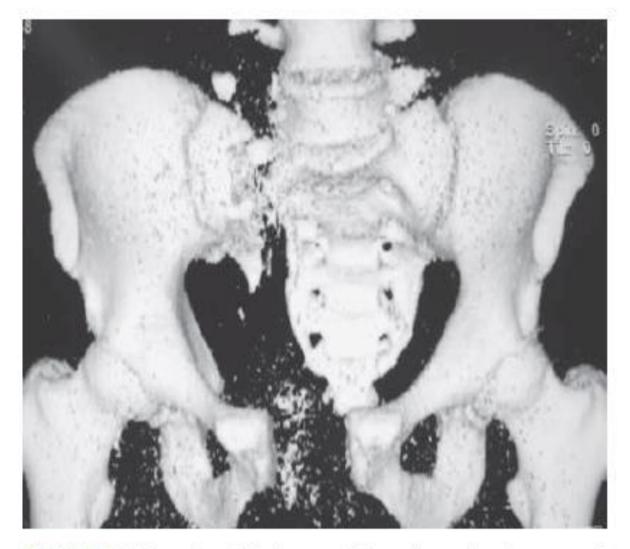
Type C pelvic fracture. Three-dimensional computed tomography scan.
